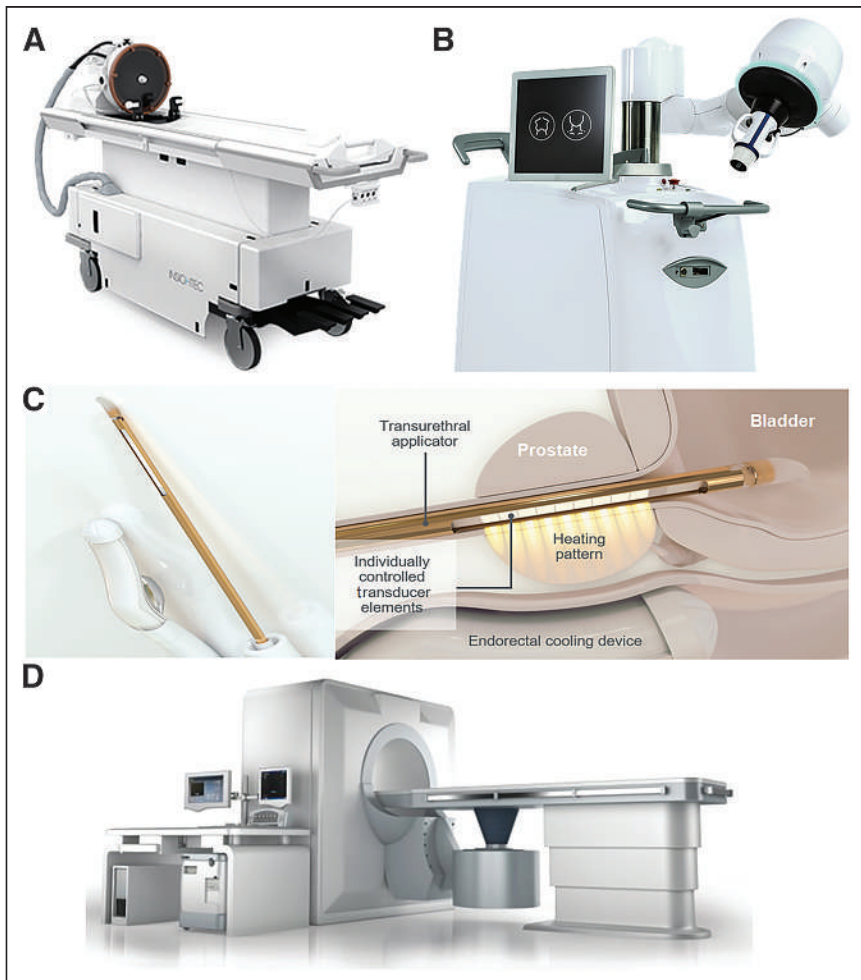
Clinically approved HIFU systems. (A) MRgHIFU system for neurologic application (ExA-plate Neuro). Patient table includes FUS transducer mounted on mechanical positioning unit with MRI-compatible head frame that can be docked to MRI scanner. (B) EchoPulse USgHIFU system for treatment of thyroid nodules and breast fibroadenomas. (C) Transurethral TUSLA-Pro MRgHIFU ablation system for prostate cancer. (D) JC USgHIFU system for solid tumor ablation of all types of soft tissue. (Images courtesy of Insightec, Theraclion, Profound Medical, and Chongqing Haifu.)
